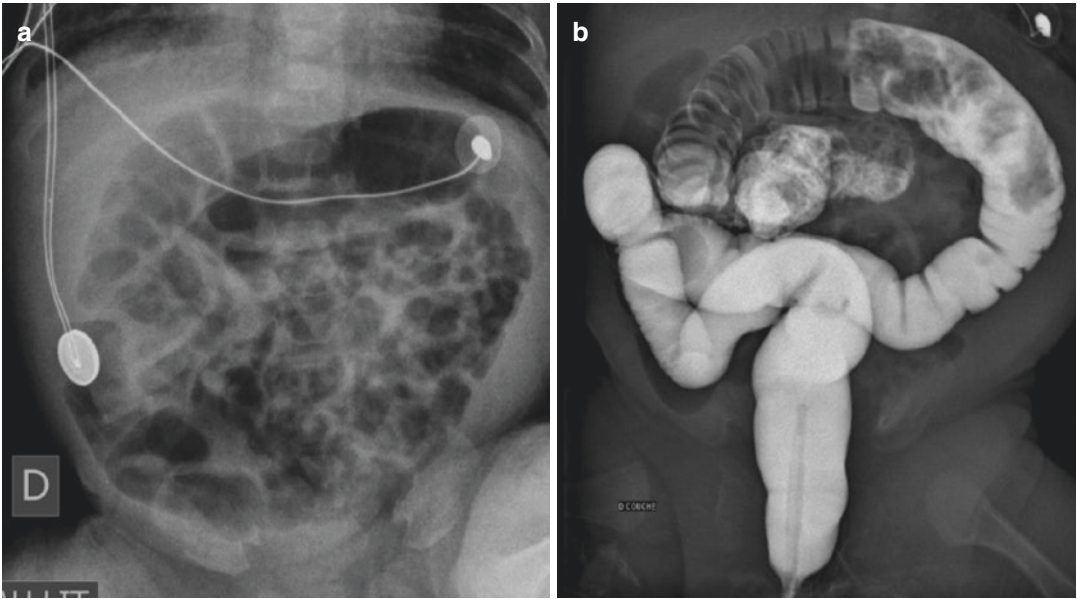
Meconium ileus equivalent in a 4-week-old premature. (a) Plain film of the abdomen showing increased intestinal distension, especially in the right flank. (b)
